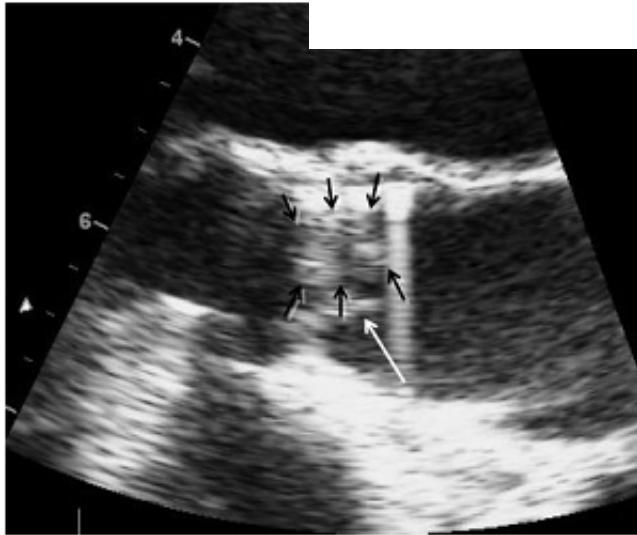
Transesophageal echocardiography (long axis) of aortic valve stent 8 months after implantation. Black arrows denote thrombus on valve stent. White arrows denote thrombus-free leaflet, which demonstrated good mobility.
